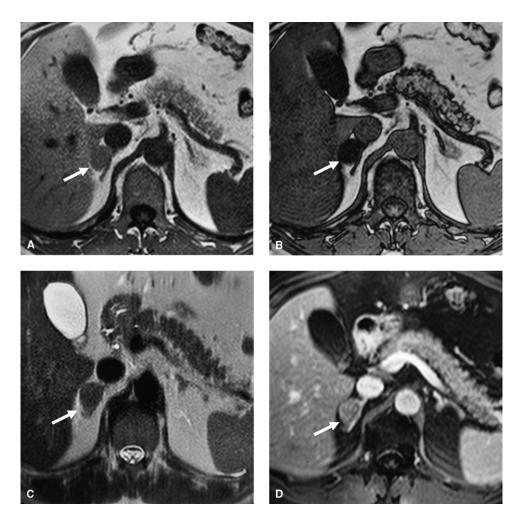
Right adrenal adenoma. Unenhanced T1-weighted in-phase (A) and out-phase (B), T2-weighted (C), and enhanced T1-weighted (D) MRI axial acquisitions. A small (diameter \sim 1.5 cm), oval mass with smooth, well-defined margins (white arrow) is detectable (A–D). The nodule has low density due to its lipid content. In fact, in the sequences based on the chemical shift phenomenon (A, B), the nodule shows an evident signal drop between in-phase (A) and out-phase (B) acquisitions. The cellular density and water content is poor as evidenced by low signal intensity on T2-weighted acquisition (C). Mild enhancement is demonstrable after gadolinium chelates CA administration, due to low vascularization (D).
